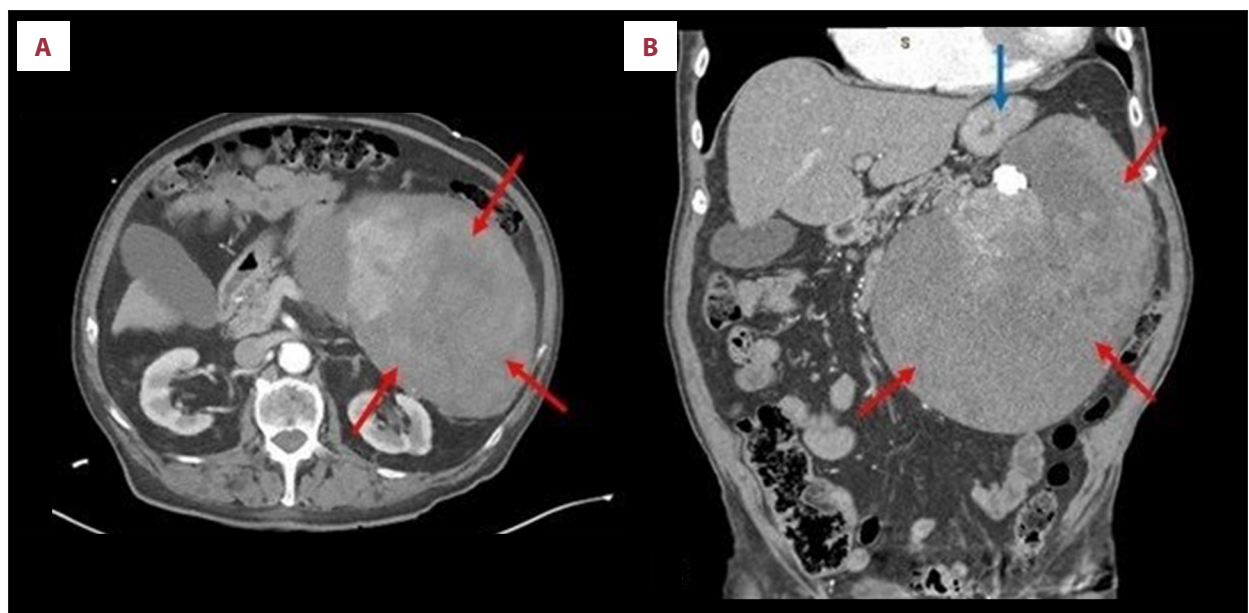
Abdominal CT scan of the benign solitary fibrous tumor. Axial scan (A) and coronal scan (B) demonstrate a 19.7×20.2×14.7 cm large complex mass (red arrows) in the left upper quadrant of the abdomen containing calcifications and hypodensities that does not seem to be arising from the stomach, spleen (blue arrow), pancreas, adrenal, or left kidney.
